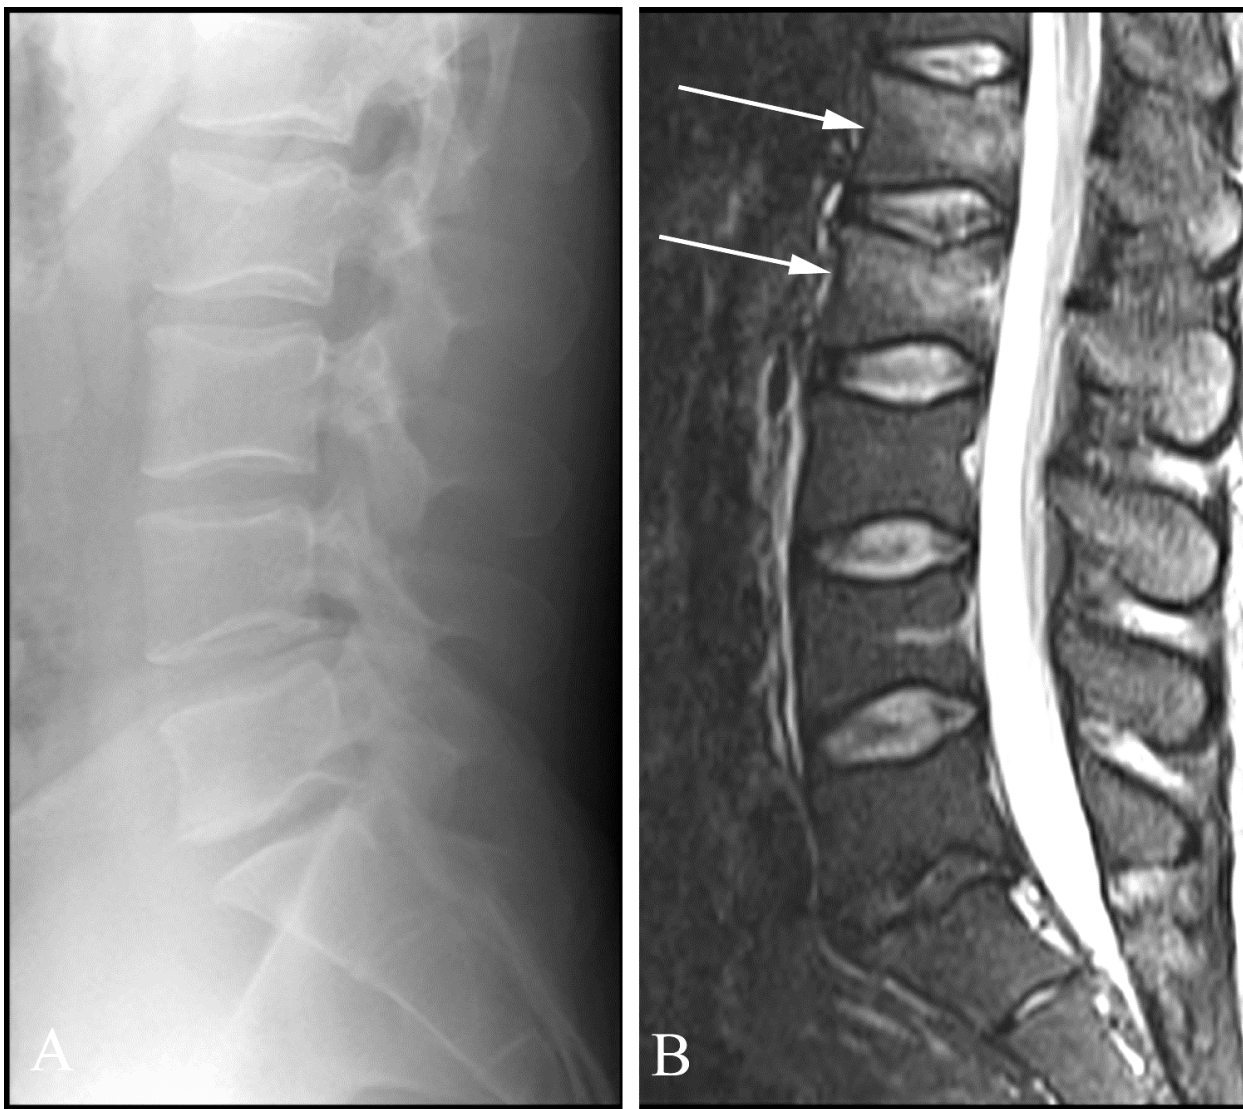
Radiographically occult post-traumatic fractures in a 39 year old man with back pain after falling off scaffolding. A. Lateral plain film of the lumbar spine taken in the emergency room is normal. The patient had persistent pain. B. Sagittal T2 spine MR (performed three days later, when pain persisted) demonstrates extensive abnormal marrow at the L1 and L2 levels (arrows) from contusion and trabecular fracture.
